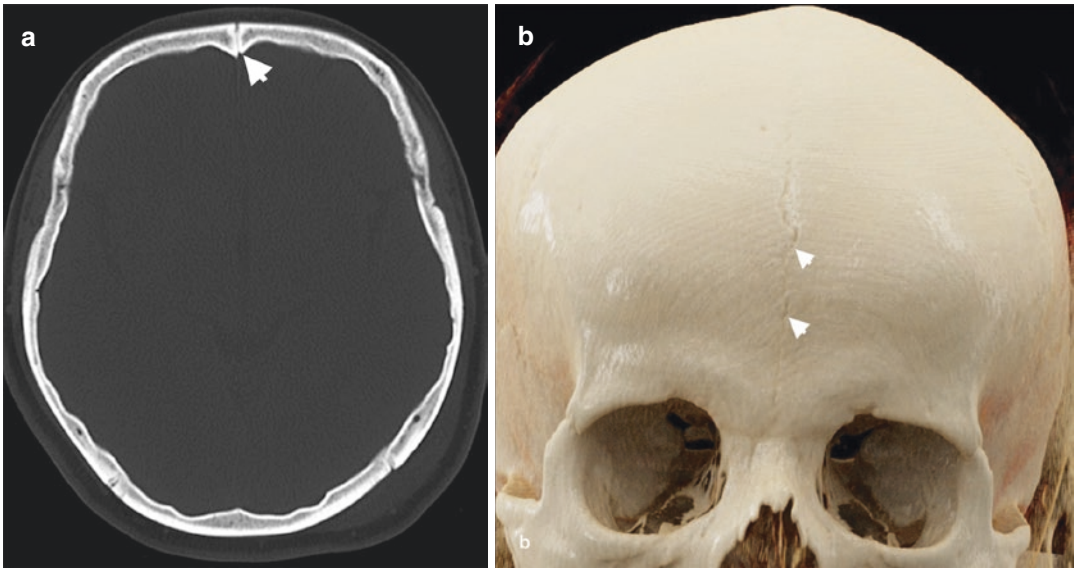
Metopic suture. Axial CT (a) and CR (b) images of a 54-year-old woman demonstrate a metopic suture (arrow-heads) in the midline extending from bregma to the nasion
